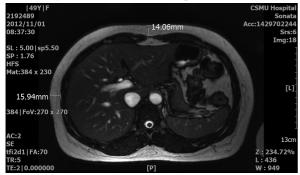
Abdominal MRI scans from 2 different subjects. Carnitine drink effectively reduced the thickness of abdominal fat layer by 1.29– 3.47 mm after 6 weeks.
